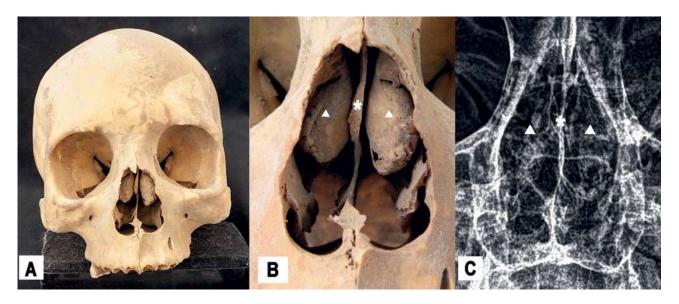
[TT16-11-2.2-FEB07-BOX13-IND01]. A, Skull – frontal view. B, Detail of bilateral and extensive *Concha Bullosa*. C, antero-posterior X-ray image of the nasal area. White triangle shows the middle turbinates, asterisk the nasal septum.
